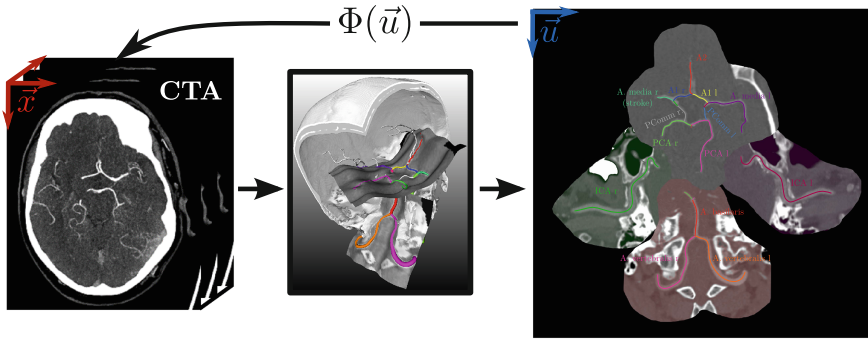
Unfolding of a labeled cerebrovascular vessel graph from a CTA volume to a 2D overview map with centerline, label and area overlay.
